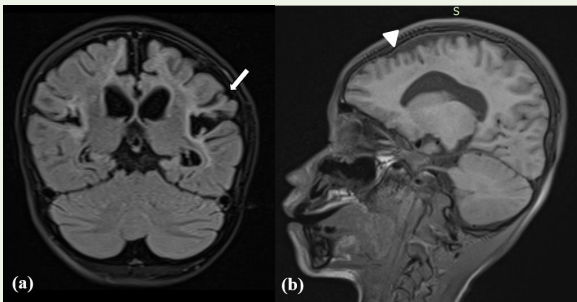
(a) Coronal FLAIR images demonstrate atrophic gyri pattern with sparing of the gyral crest giving a mushroom shaped (Ulegyria) morphology (white arrow) with increased FLAIR signal in the subcortical white matter of parietal lobes and volume loss. (b) Sagittal T1 weighted image shows a simplified frontal gyral pattern (white arrowhead).
